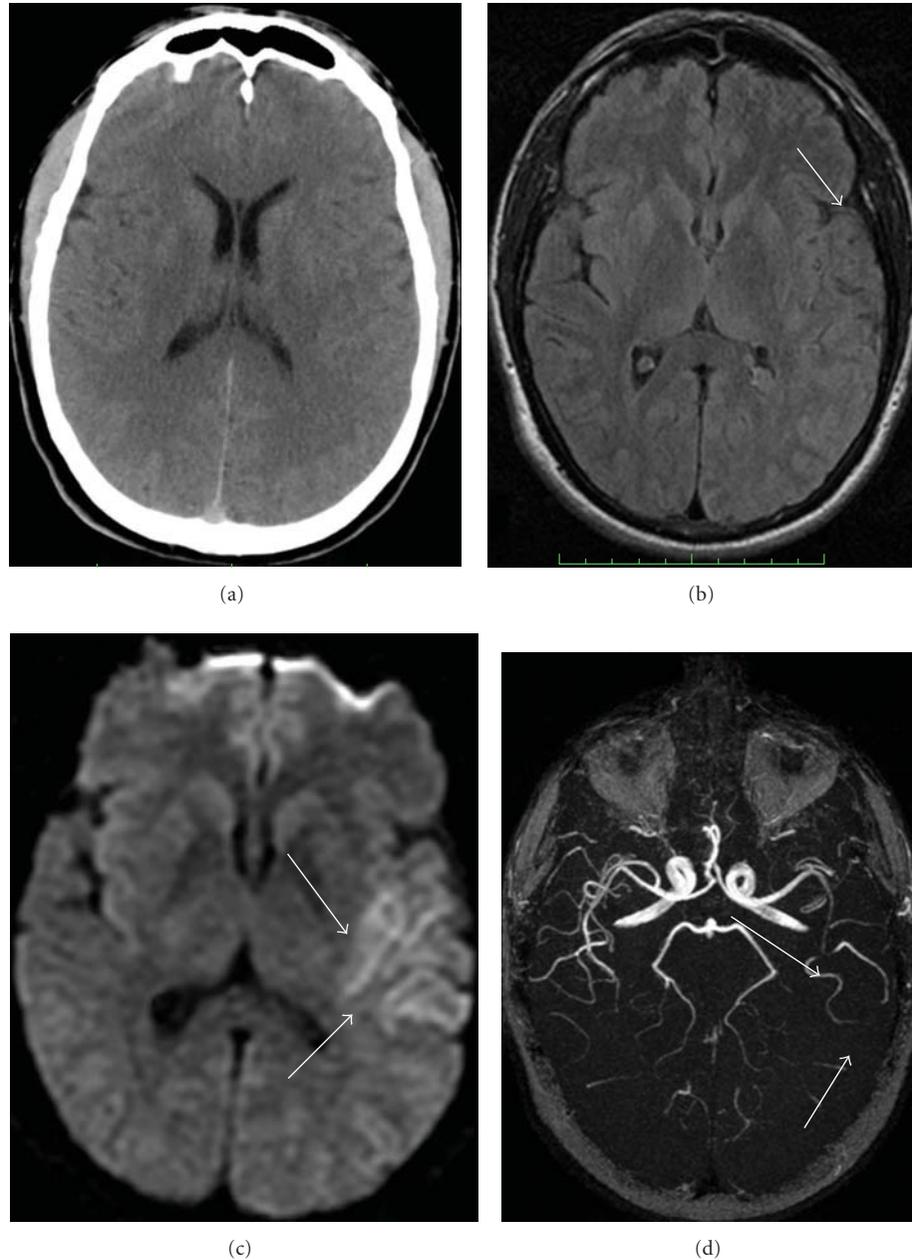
A 14-year-old male with right-sided hemiparesis started 3 hours before MRI. (a) Plain CT scan does not show significant density abnormality. (b) MRI T2-weighted Fluid Attenuated Inversion Recovery image does not show significant signal intensity abnormality of cerebral parenchyma even if hyperintensities of distal branches of middle cerebral artery are visible and suggest vessel occlusion (arrow). (c) MRI Diffusion-weighted image shows bright signal of left insular and temporal cortex indicating cytotoxic edema (arrows). (d) 3D-Time of Flight MR-angiogram shows poor representation of distal branches of left middle cerebral artery (arrows).
